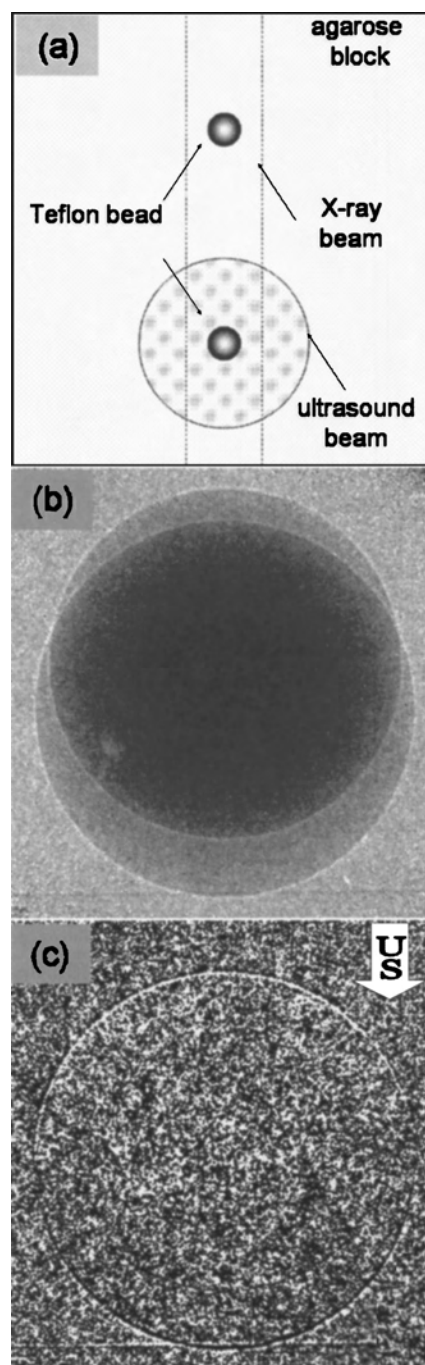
(a) Top view of the sample consisting of two Teflon beads cast in agarose. The two beads are separated by 3 cm. (b) Conventional phase contrast image of two Teflon beads in agarose and (c) an acoustically modulated phase contrast image showing only the bead irradiated with ultrasound. The beads were located 2.5 cm apart.
